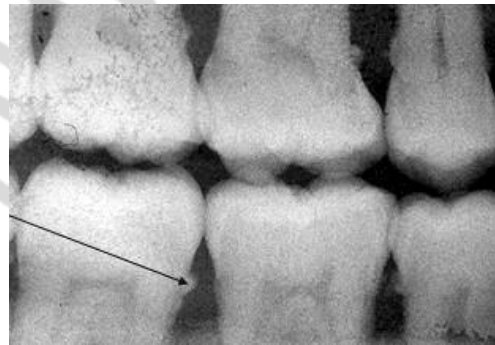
Detection of calculus at roentgenogram
